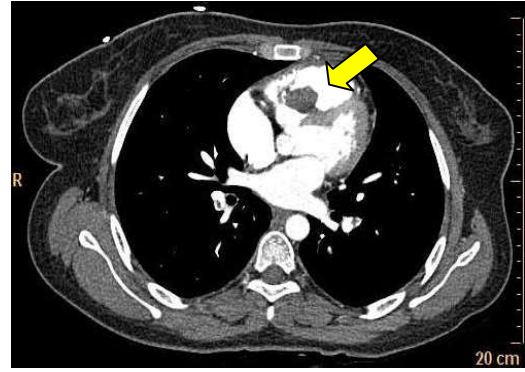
CT-PA demonstrates clearly a hypodense mass attached to the inter-ventricular septum in the RV. (Dimensions: 27.0*20.0*28.0mm)
